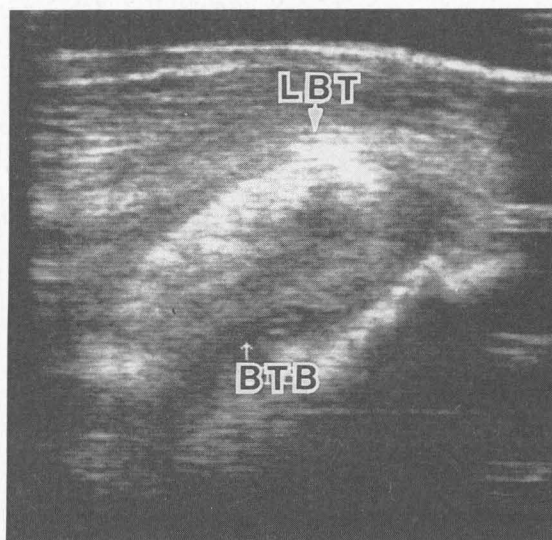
Ultrasonogram (transverse scan) of the right bicipital tendon. Notice fluid in the bicipital bursa. LBT = lateral portion of the biceps tendon; BTB = biceps tendon bursa.
